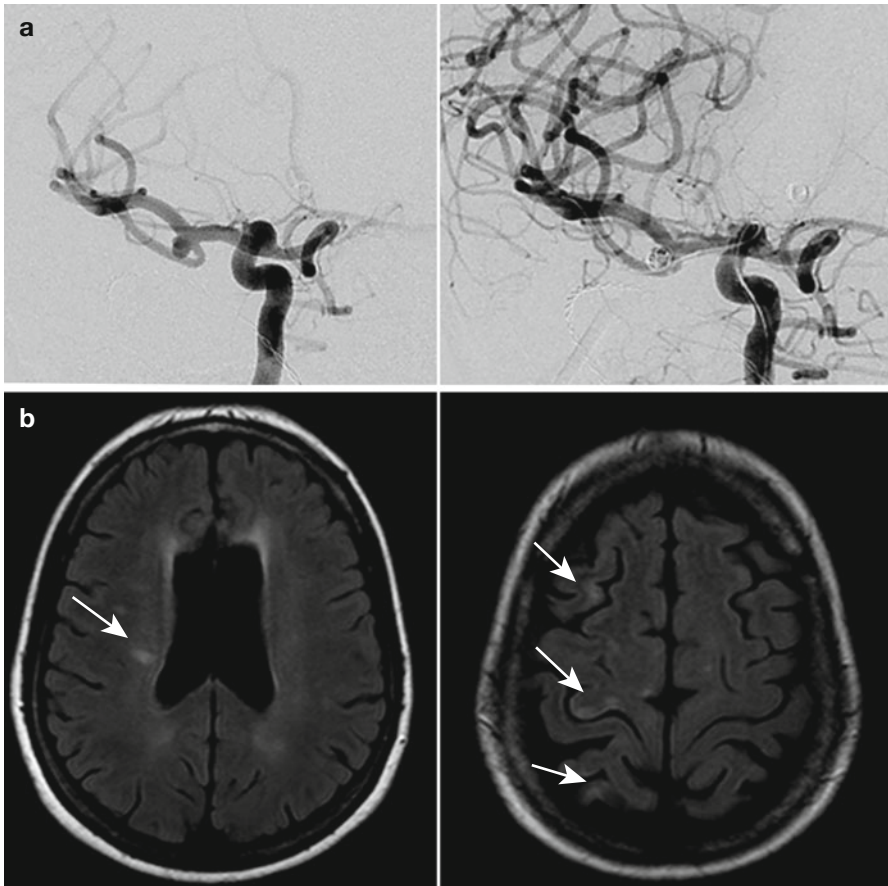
Watershed ischemia post-balloon remodeling of right MCA aneurysm. (a) Pre- and post-angiograms using remodeling technique. MRI study post-embolization of right MCA aneurysm using remodeling technique. (b) FLAIR; (b) DWI; (c) ADC; (d) Maps show area of deep (*left*) and superficial (*right*) MCA watershed ischemia – white arrows show infarction
